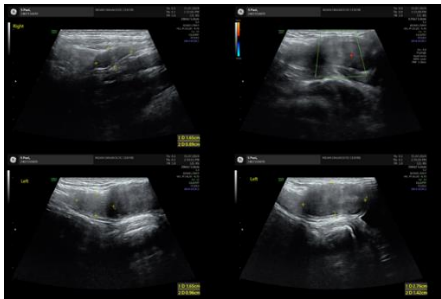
Ultrasonography of inguinal region shows absence of bilateral ovaries and uterus and presence of bilateral testis with a small focus of neoplastic pole on the left.
